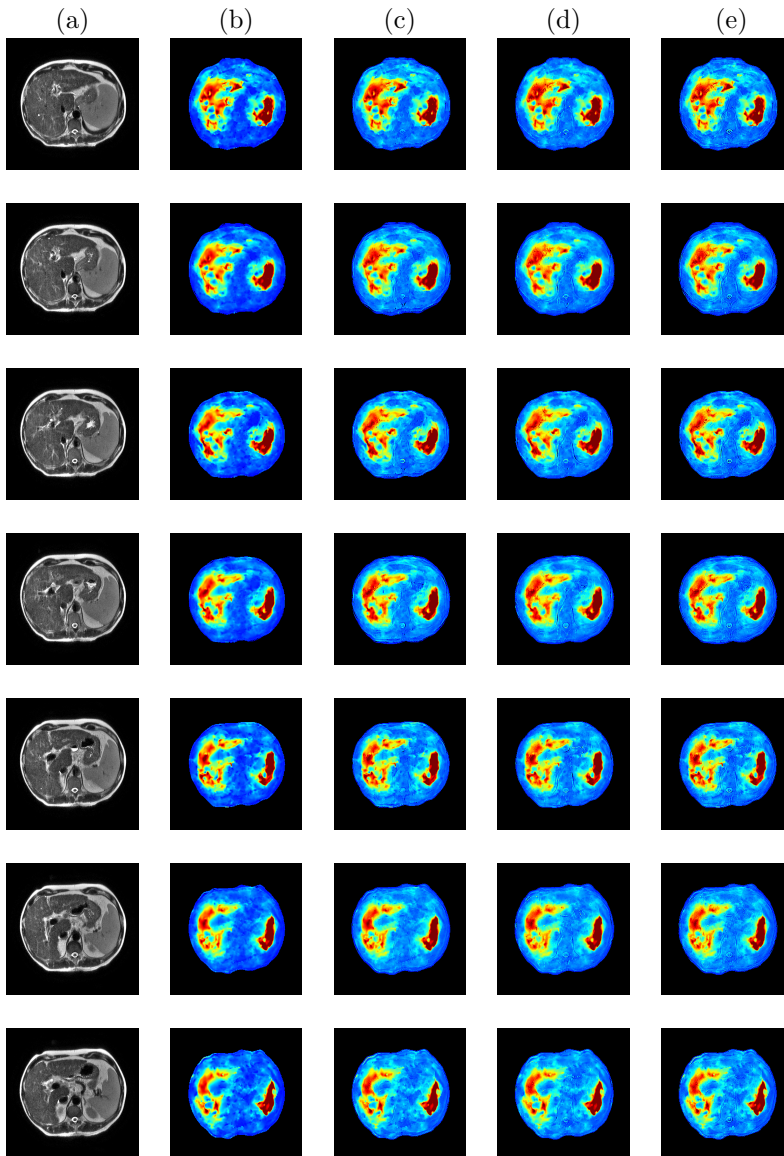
Fusion results for the Patient2 dataset. Each row is related to a specific slice,  $k = 1, \dots, 7$ . Columns are organized as follows: (a) original T1 MRI; (b) expanded MRE; (c) ADM-LG; (d) GTF; (e) ATWT.
